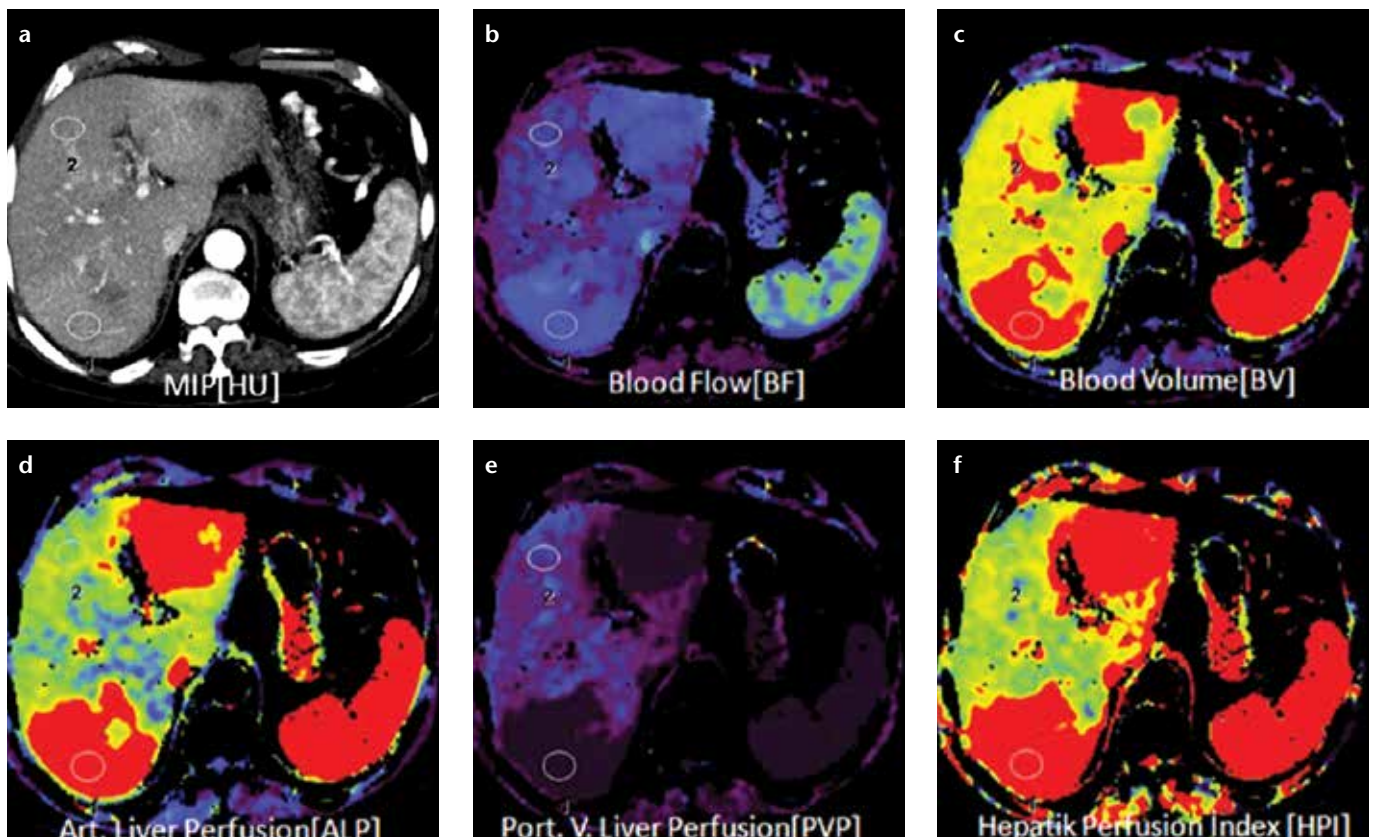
a–f. Axial perfusion images (a) and functional CT perfusion map (b–f) of a 70-year-old woman with liver metastasis from pancreatic adenocarcinoma. The perfusion images show increased BF, BV, and ALP compared with normal liver parenchyma.
